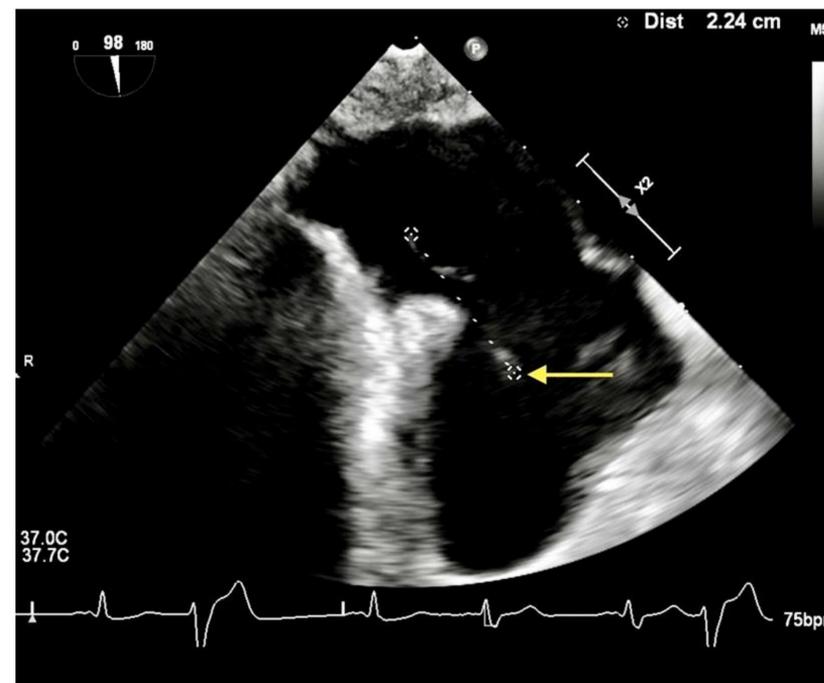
Transesophageal Echocardiogram showing a mobile echo dense mass (yellow arrow) attached to the Chiari-Eustachian valve complex within the right atrium. The top right corner estimates the two dimensional length and width of the mass in centimeters (cm).
